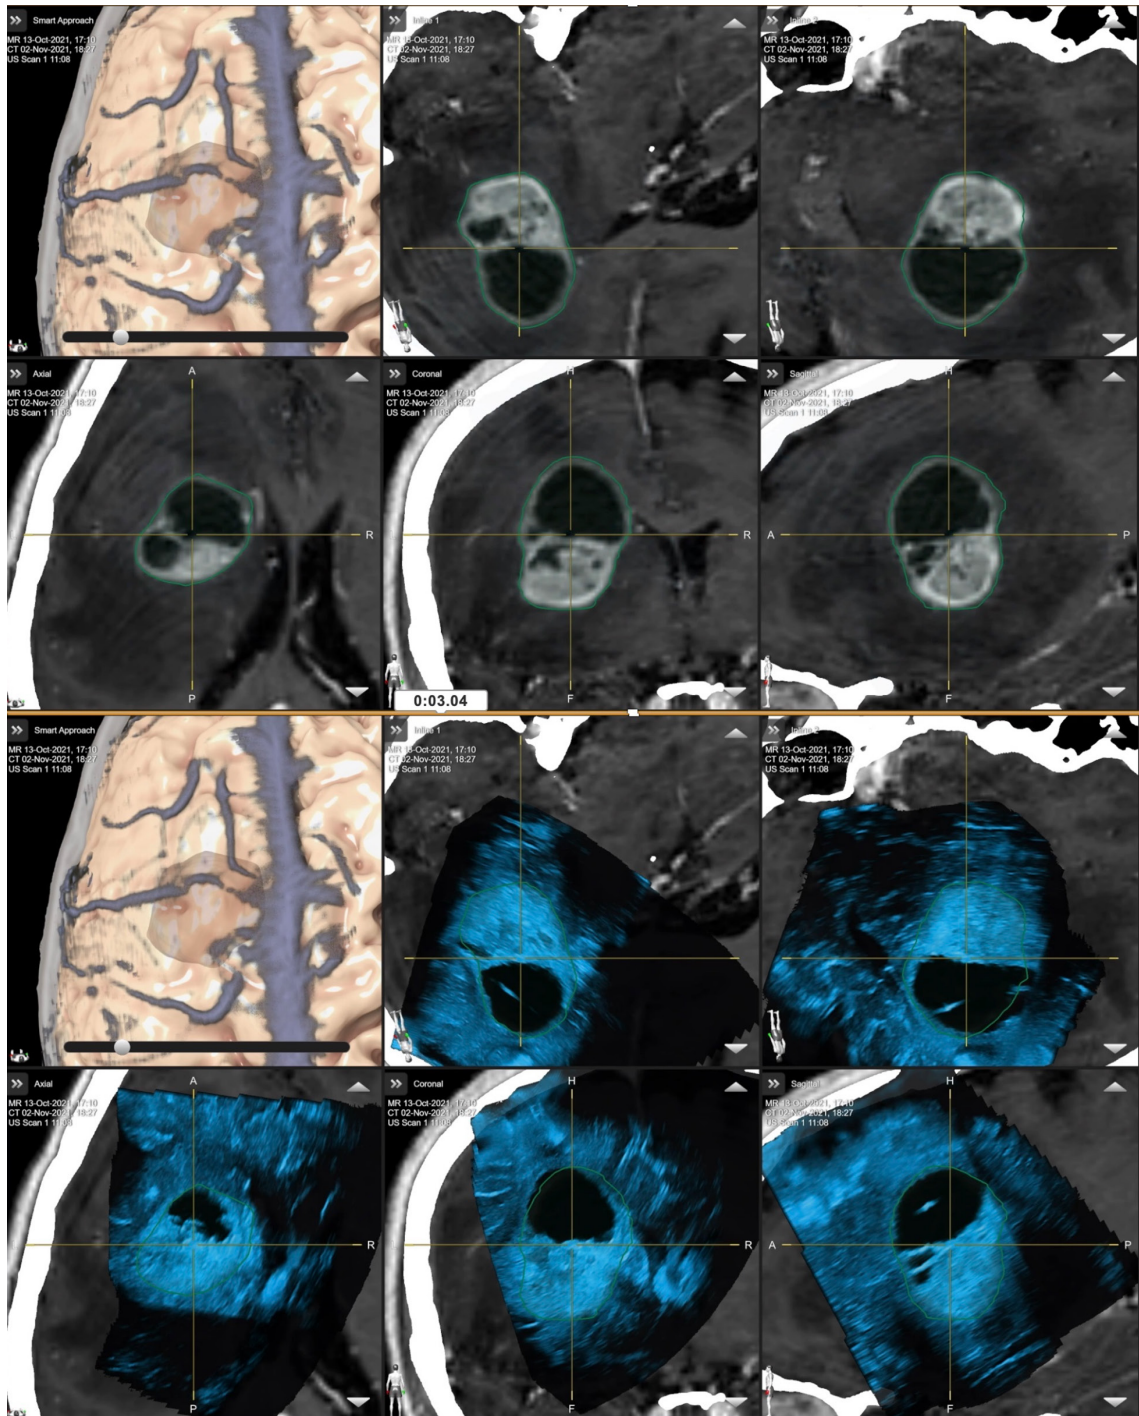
Modern intraoperative neuroimaging tools: neuronavigated ultrasound (US)
